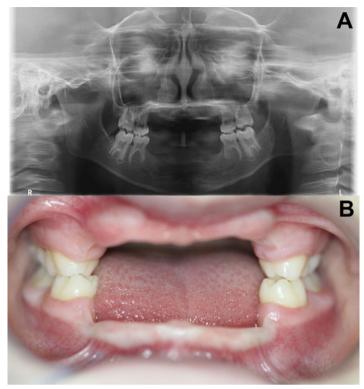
Panoramic radiograph without evidence of embedded teeth or tooth germs (A); intraoral photograph showing absence of multiple teeth (B)
